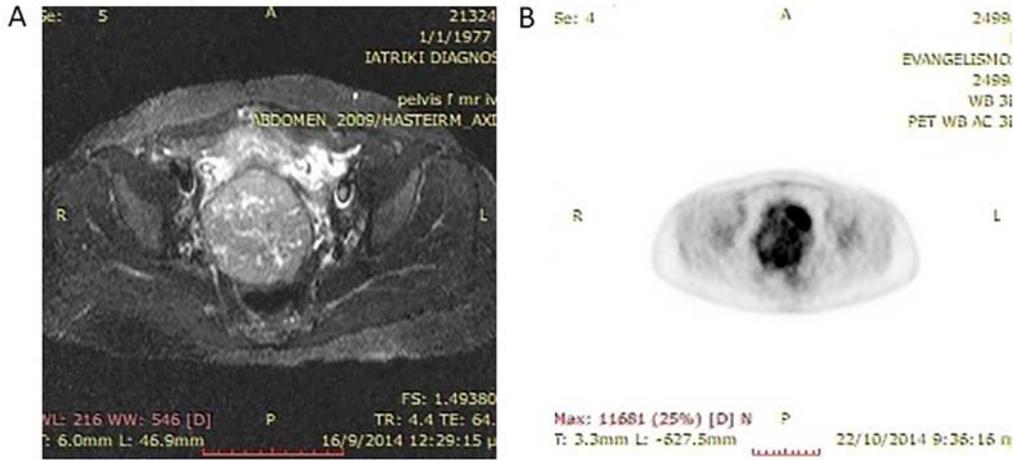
(A) MRI of abdomen and (B) PET-CT showing the tumor.
